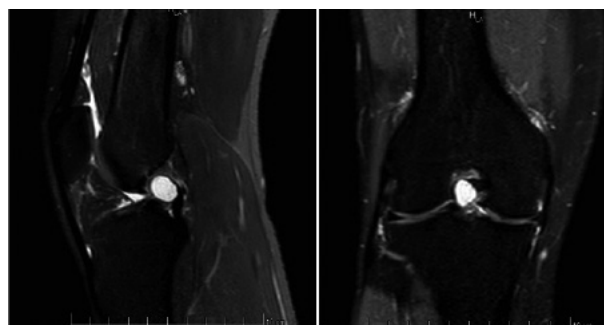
Hyperintense anterior cruciate ligament associated ganglion cyst in a T2-weighted MRI.
